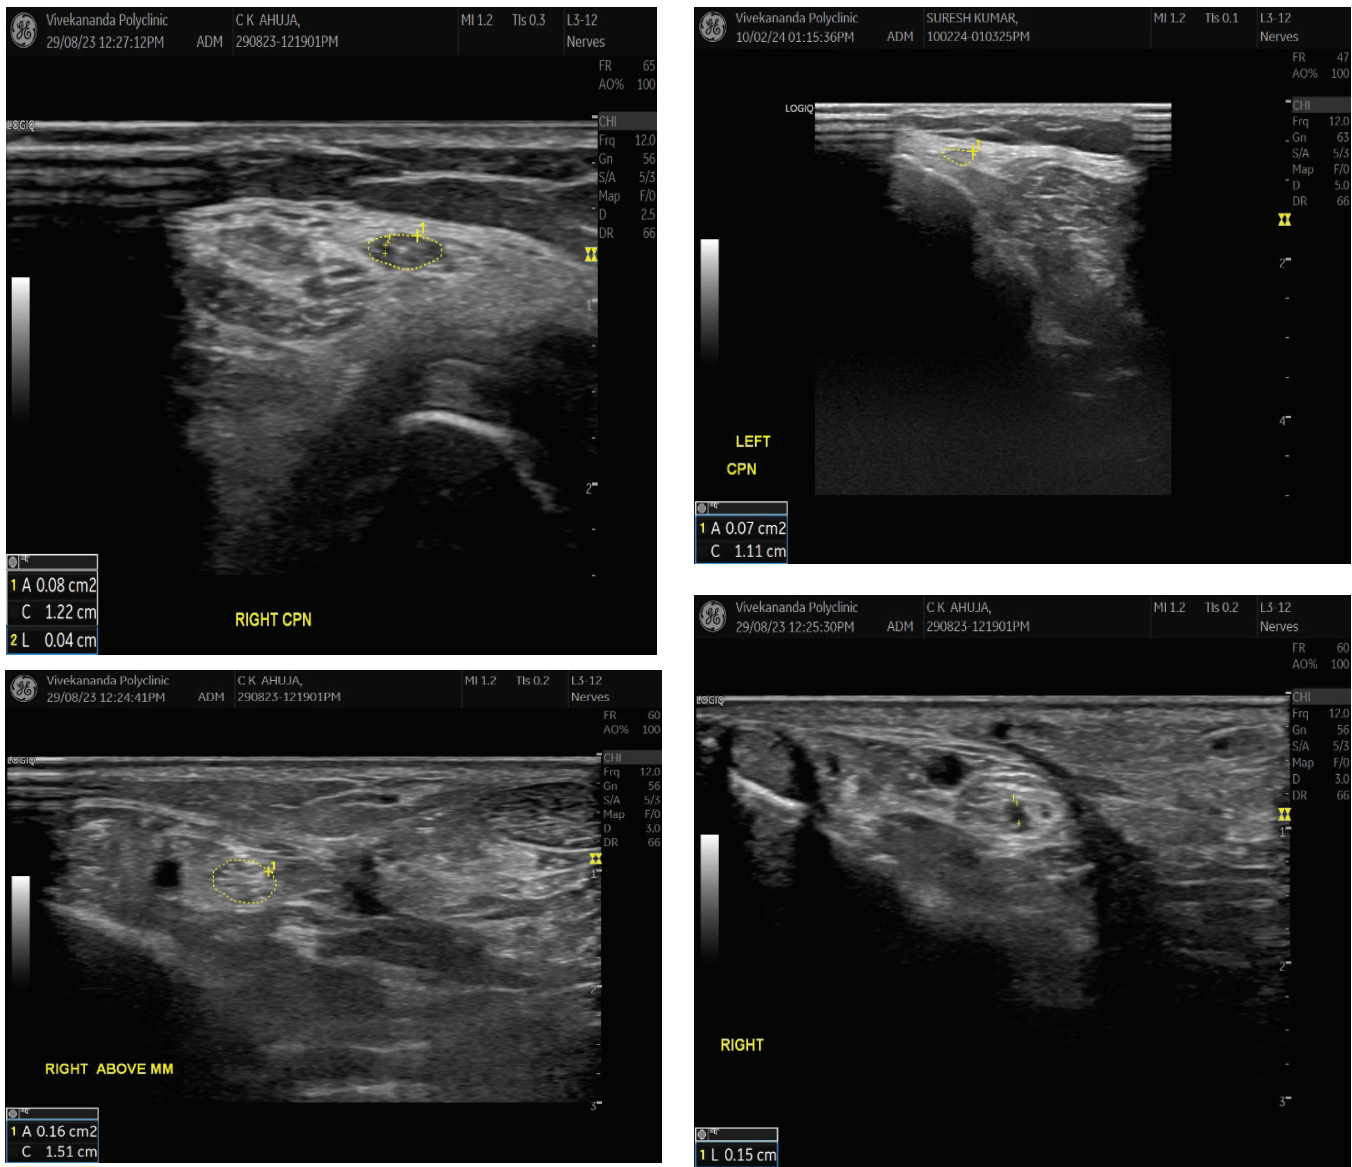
Case 3- A 56-years-old male patient diagnosed with Type-2 Diabetes Mellitus 14-years back, presented with pain and swelling in both lower limbs. His HbA1c was 9.8% and his RBS was 375 mg/dL. A. A transverse sonogram view of the tibial nerve at 3 cm proximal to Medial Malleolus (MM) showing thickened tibial nerve with Cross section area (CSA) measuring 16 mm². B. Mean Thickness of Nerve Fascicle (MTNF) of tibial nerve was increased measuring 15 mm. C. A transverse sonogram view of normal Common Peroneal Nerve (CPN) at fibular neck level with CSA of 7 mm². Mean Thickness of Nerve Fascicle (MTNF) of Common Peroneal Nerve (CPN) was increased measuring 7 mm.
